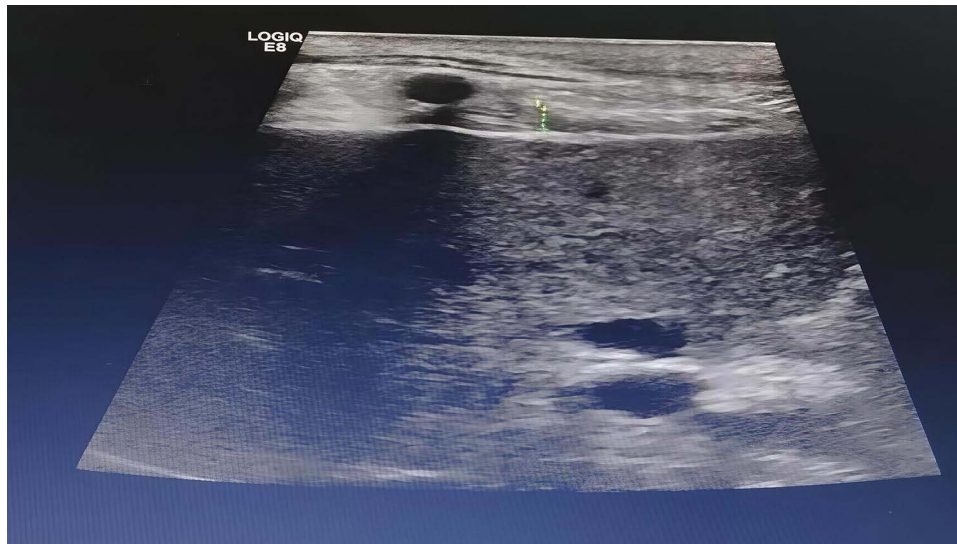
Ultrasonographic measurement of DTee. The same anatomical landmarks as in Figure 4 are used (pleural line and peritoneal line as hyperechoic boundaries). Thickness is measured at the end of expiration, when the diaphragm is at its most relaxed position. Table 1. Severity-Graded Exercise Rehabilitation Programme for AECOPD Patients.
